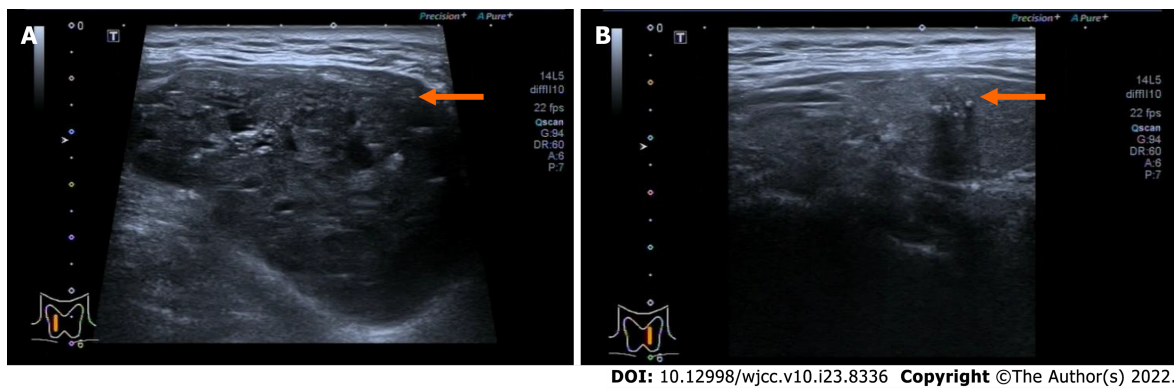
Cervical ultrasound of the patient before surgery. A: The right-side nodule (orange arrow) was 58 mm × 41 mm × 67 mm and was classified as TI-RADS 4A; B: The left-side nodule (orange arrow) was 6.4 mm × 8 mm × 8 mm and was classified as TI-RADS 4C.
